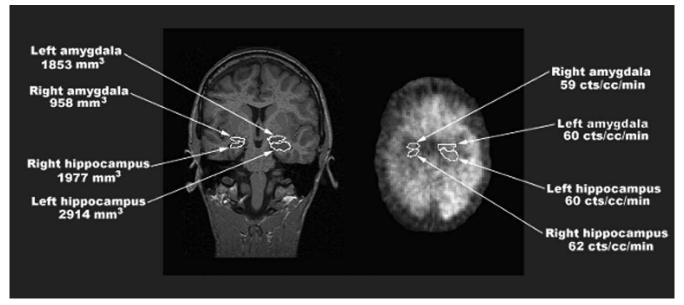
Quantitation of hippocampus and amygdala MRI regions and the use of MRI-PET co-registration to obtain FDG concentration per unit volume in FDG-PET (2-dimensional original slices shown here).
